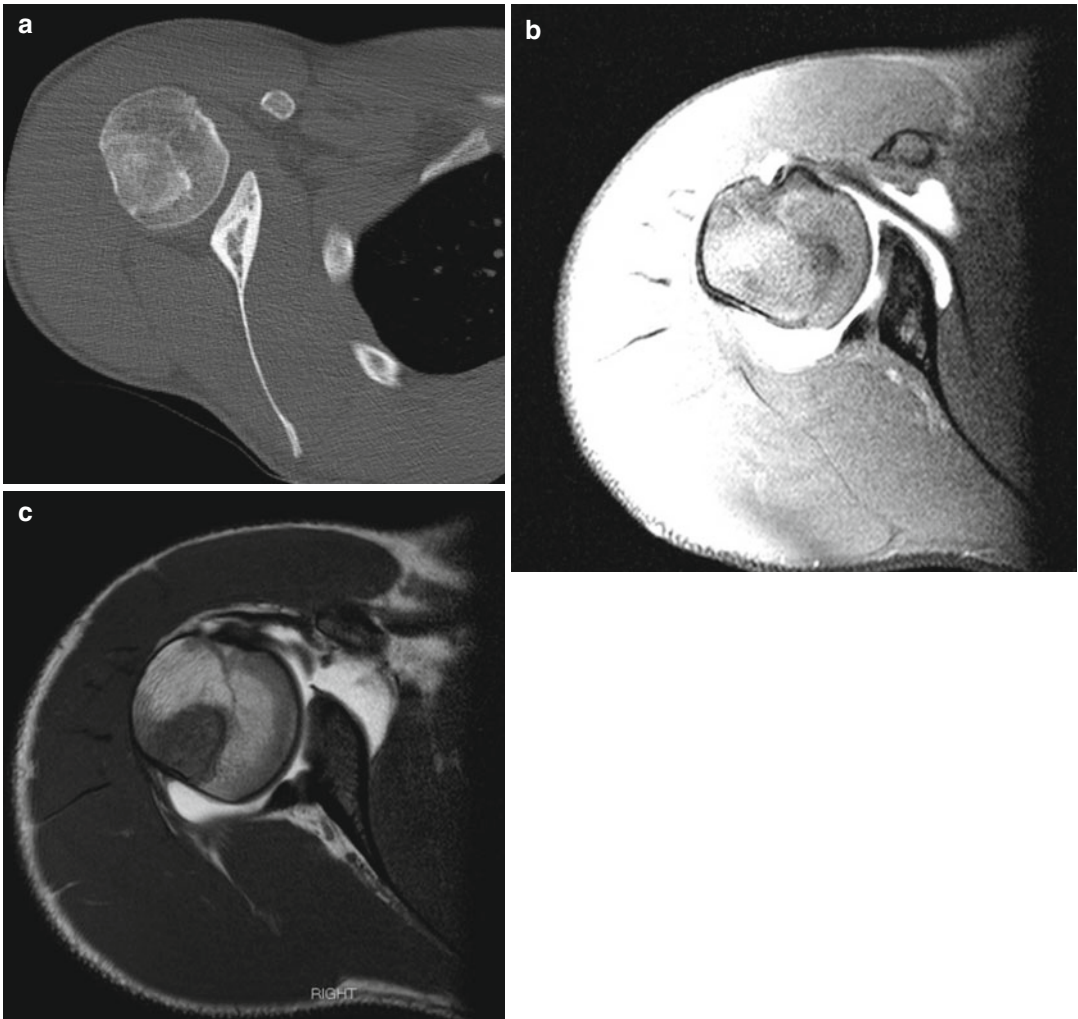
Dysplastic glenoid on CT scan (a), MRI arthrogram T1 (b), MRI arthrogram T2 (c)
